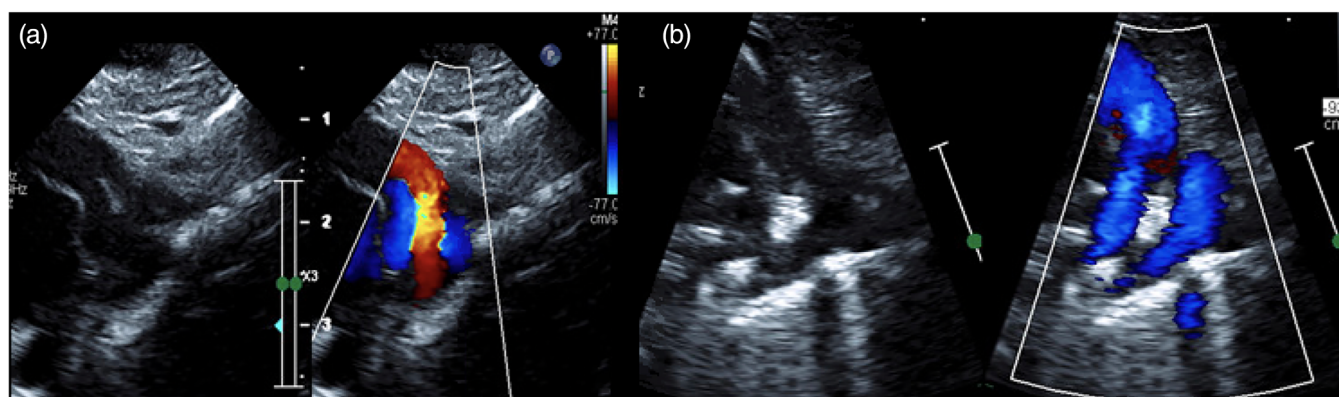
Transcatheter patent ductus arteriosus (PDA) occlusion with Micro Plug Set: echocardiography. Intra-procedural echocardiography: Suprasternal views of the PDA (red) and left pulmonary artery (blue) prior to device placement in 2D and color (panel a). Subsequent echocardiography, post PDA device (echo-bright) occlusion, showing unobstructed color flow in the LPA and descending aorta (panel b) [Color figure can be viewed at wileyonlinelibrary.com]
